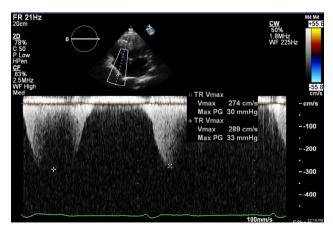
Echocardiography showing mild to moderate tricuspid regurgitation.
